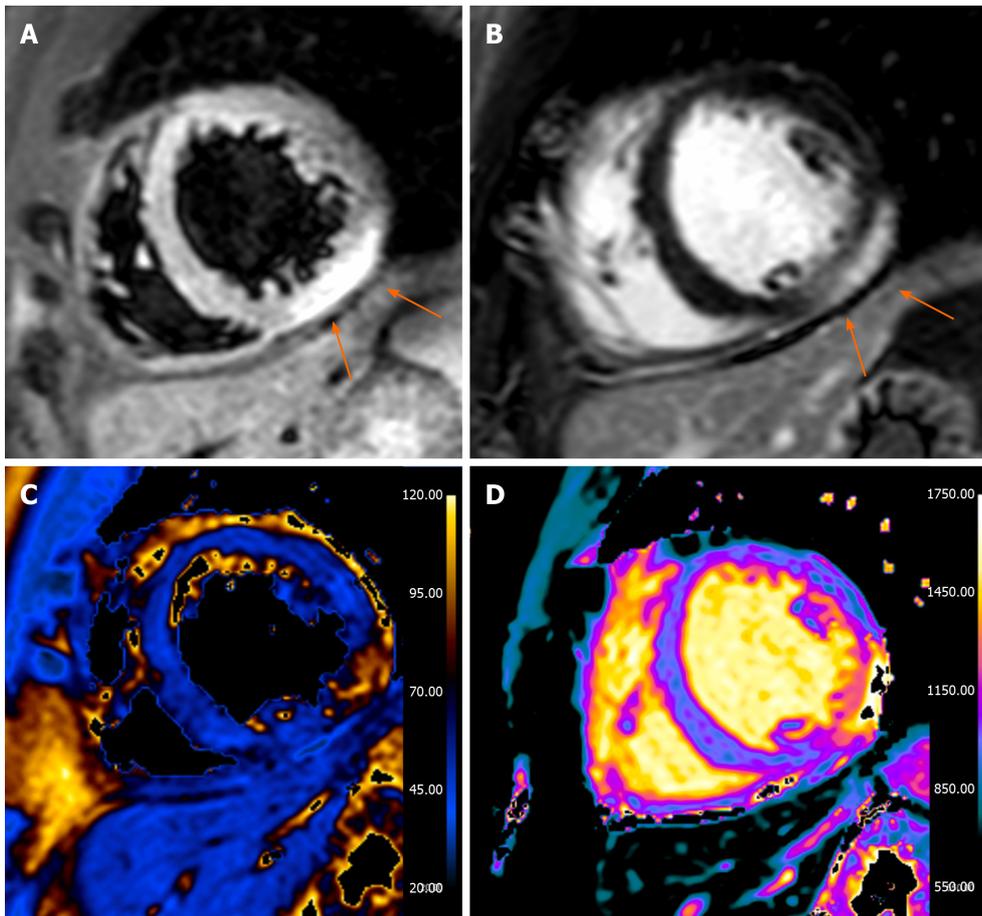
Thirty-seven years old male presented with acute chest pain, increased troponin values and negative invasive coronary angiography. A: A short axis T2-weighted short-tau inversion recovery image, a subepicardial and hyperintense areas is seen in the infero-lateral wall (arrows); B: Late gadolinium enhancement image with evidence of the same alteration (arrows); C: T2 map; D: T1 map. The cardiovascular magnetic resonance study is in keeping with acute myocarditis.
